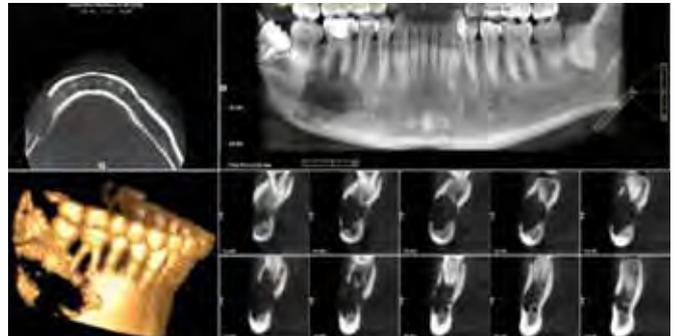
CT (computed tomography) image of the mandible revealing a rapidly growing, ill-defined unilocular radiolucency (four weeks after initial presentation).
